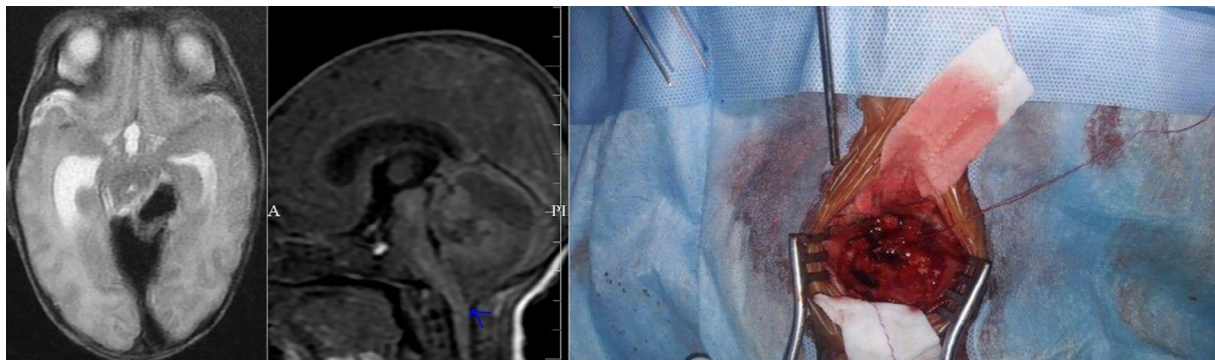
a) MRI (T2) image showing subdural hemorrhage in the posterior cranial fossa b) Evidence of tonsillar herniation c) Clots visualized on posterior craniotomy.
